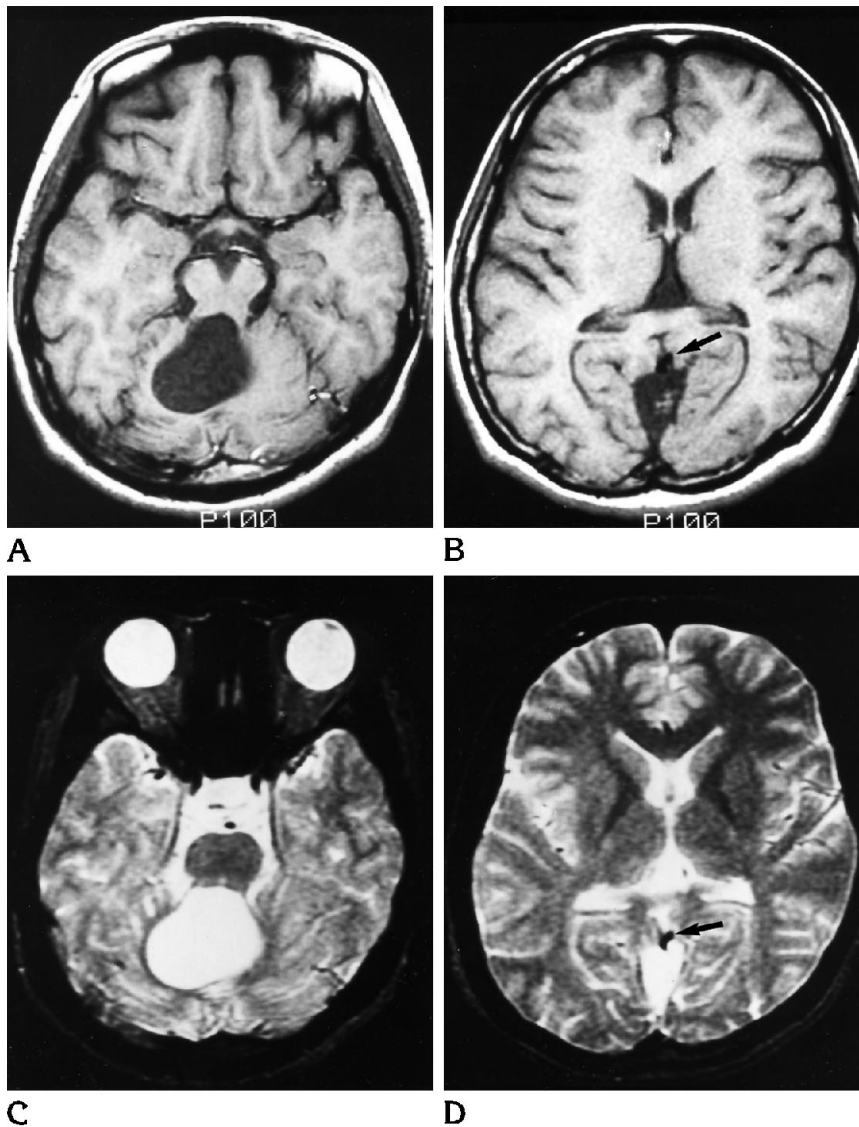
Axial T1-weighted MR images (500/20) (A and B) and corresponding T2-weighted MR images (2500/80) (C and D). The MR appearance of the dermoid cyst is of mixed hypointensity on T1-weighted sequences and hyperintensity on T2-weighted sequences. *Arrows* indicate the straight sinus.
